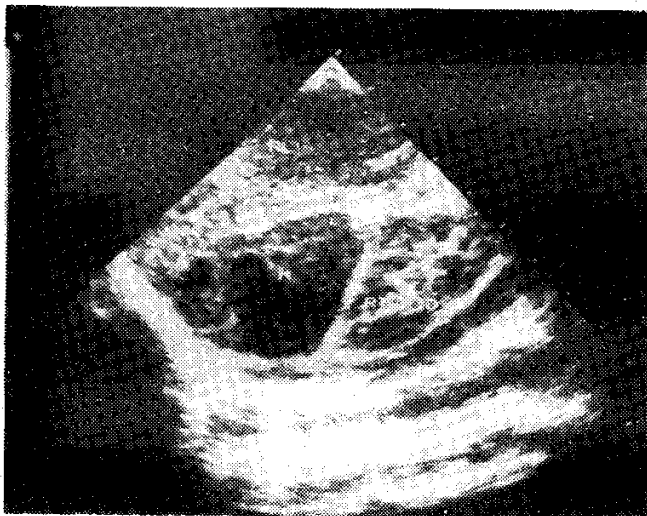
Sonogram of same patient 30 days later now demonstrates the suprarenal mass to be predominantly sonolucent.
